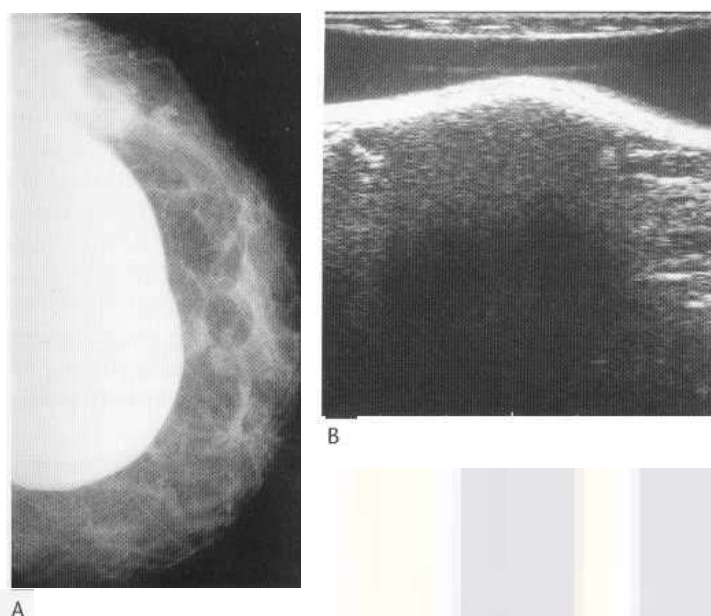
(A) Implant with silicomoma formation. A firm mass was palpable adjacent to the lateral aspect of the implant. The craniocaudal view shows a soft-tissue opacity with irregular margins adjacent to the lateral aspect of the implant. There are several small round nodules in the adjacent breast tissue. (B) Ultrasound at the site of the mass shows acoustic shadowing only.
